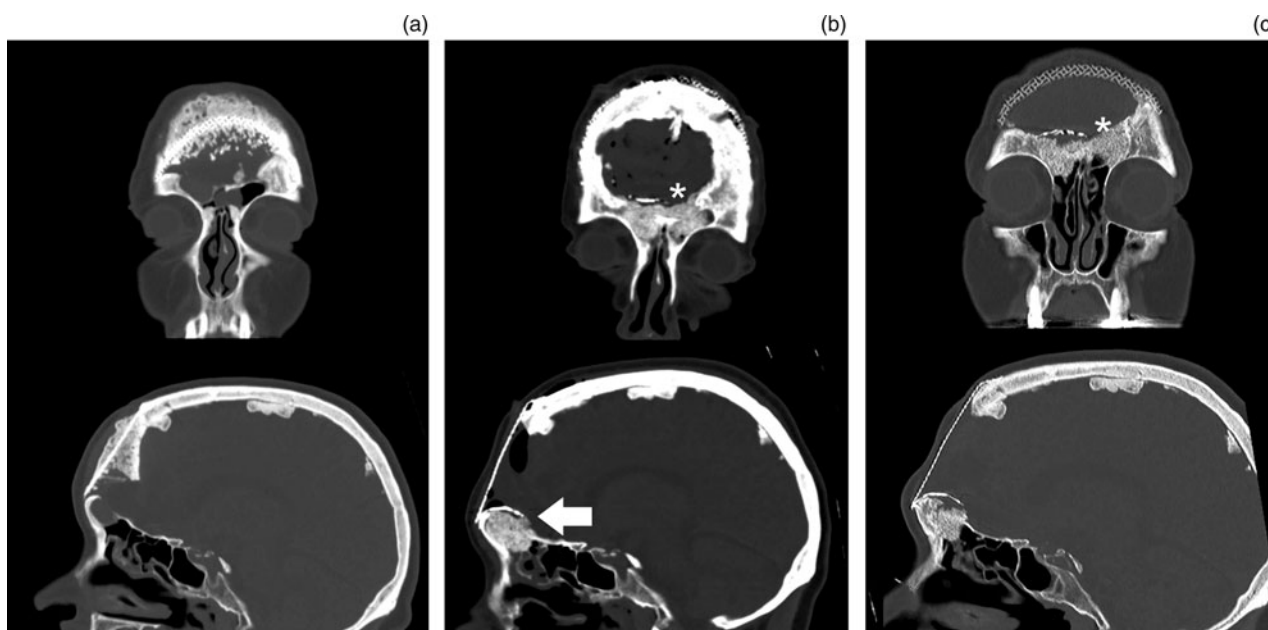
Patient 1 – non-contrast, coronal and sagittal computed tomography bone window images of the frontal sinus and anterior skull base defect: (a) pre-operatively, (b) day 1 post-operatively and (c) 6 months post-operatively, demonstrating osseous integration (large arrow) of the beta-tricalcium phosphate/hydroxyapatite graft and resolution of the meningocele (asterisks).
